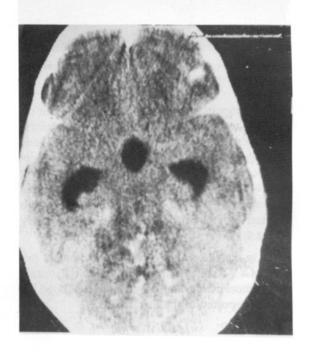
Preoperative CT scans revealed a vermian mass without demarcation. The lesion contains areas of calcification. The IVth ventricle is not visible.
